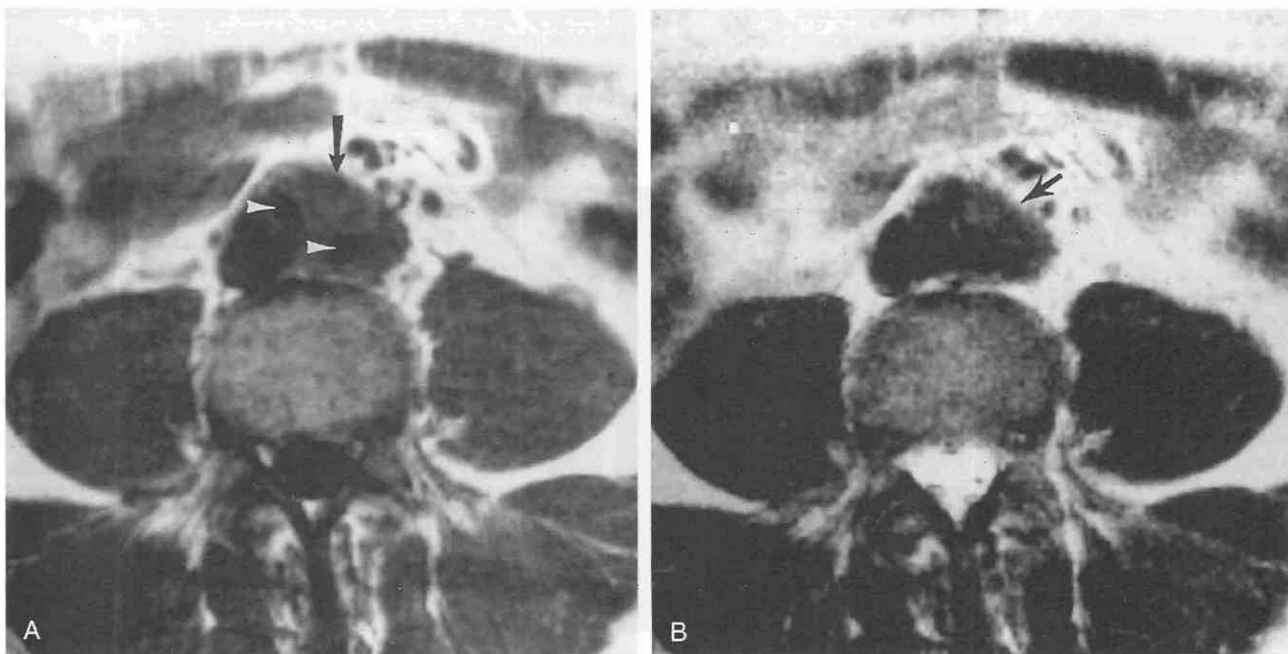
Retroperitoneal fibrosis. A, T1-weighted, spin-echo MR image demonstrates a low-signal-intensity, plaque-like mass (arrow) surrounding the proximal portions of both common iliac arteries (arrowheads) and the caudalmost aspect of the inferior vena cava. B, On the T2-weighted, spin-echo image, the mass (arrow) is again of very low signal intensity, a finding consistent with the presence of extensive fibrous tissue with little or no active inflammation.
